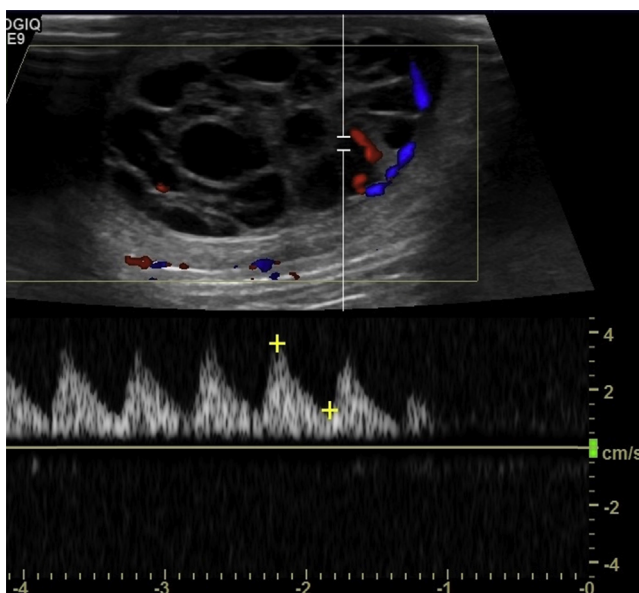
Sonogram with Doppler demonstrating minimal bloodflow to lesion.
